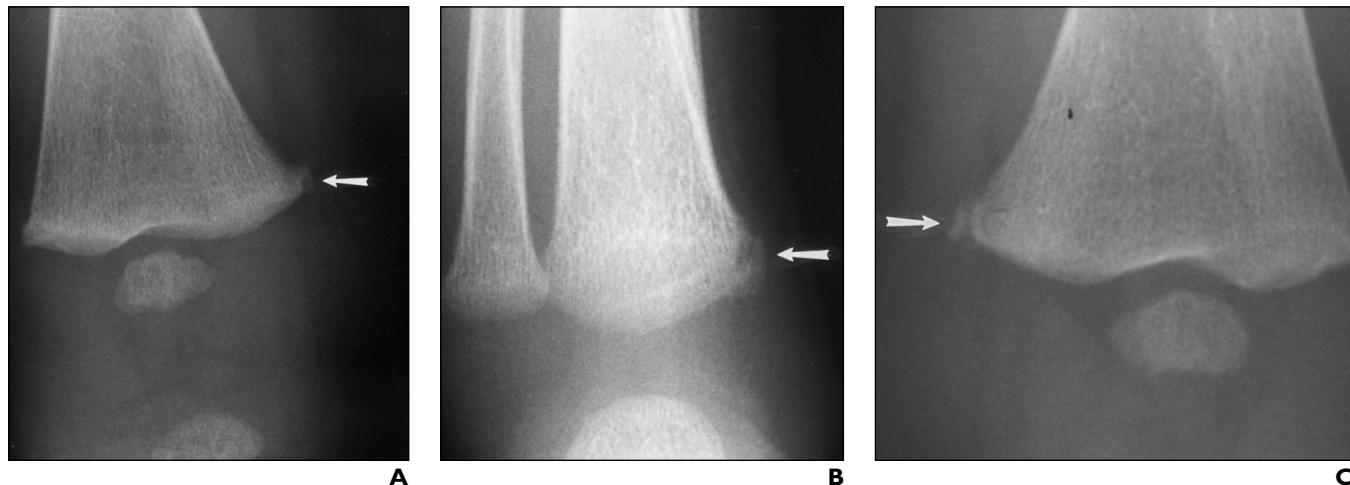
11-week-old male infant with blunt force injuries of chest and abdomen. Extremity fractures and healed rib fractures were detected only on postmortem radiography. Acute rib fractures were revealed both at autopsy and on postmortem radiography.
